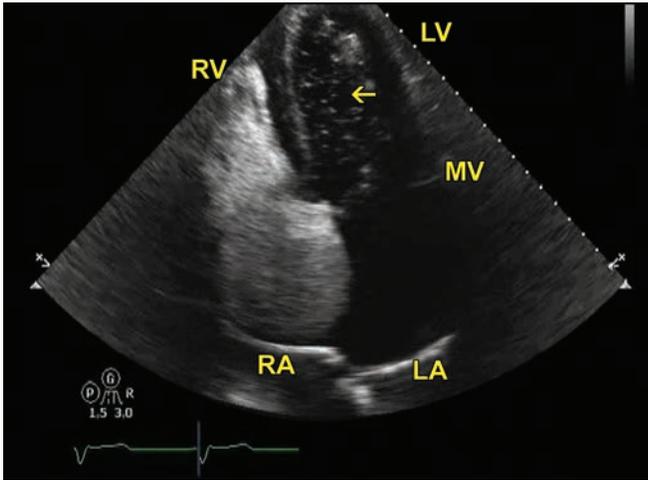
Apical 4 chamber with ultrasound contrast. Arrow points to bubbles appearing in the LV.
